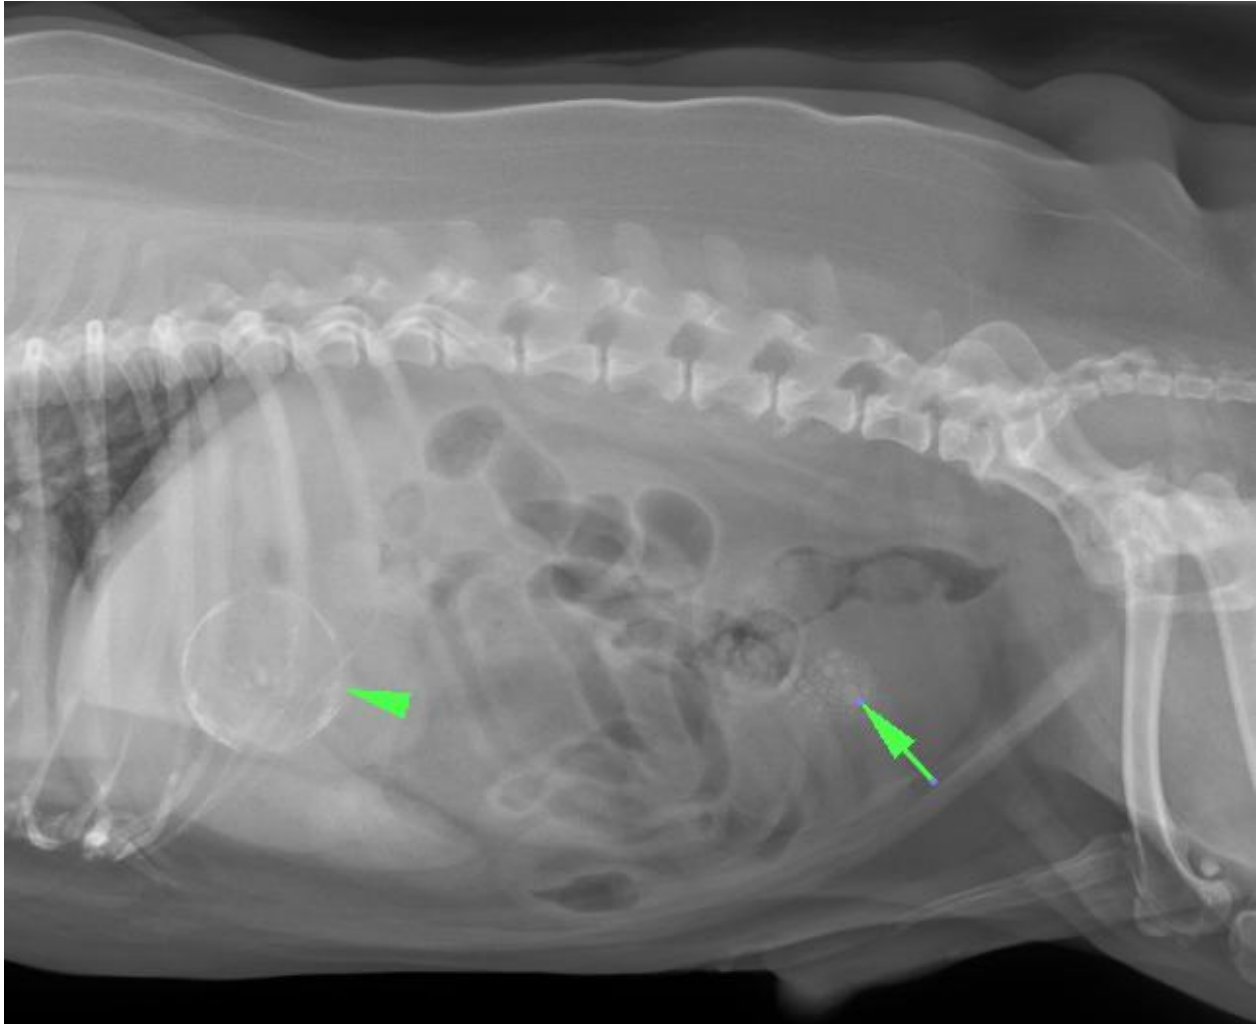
The right lateral abdominal radiograph showed that the gastric axis was parallel to the rib bone, the liver margin was sharp but the cranioventral abdomen which was beneath the gastric pylorus showed a ring shape, faint mineralization (3.8×3.8 cm, arrow head). Besides, there was a moderate amount of radiopaque sand calculi in the bladder (the largest diameter was 4.8 mm; arrow).
